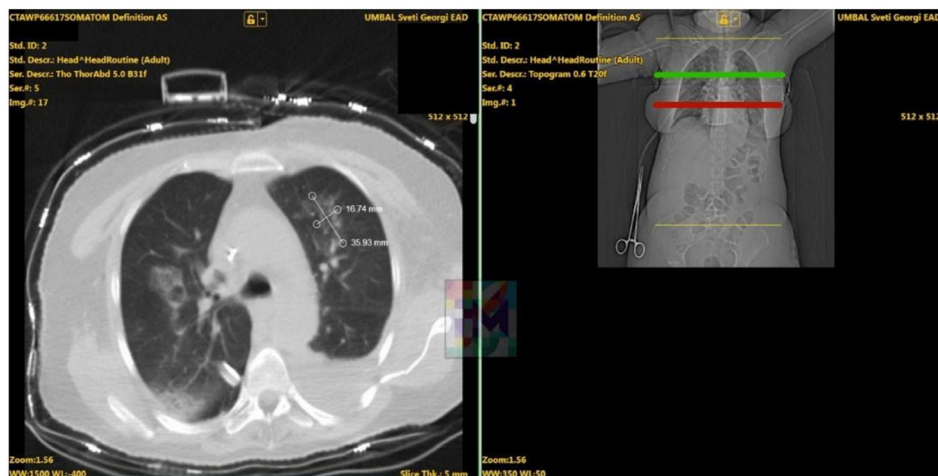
A CT scan of a patient with chest trauma.
